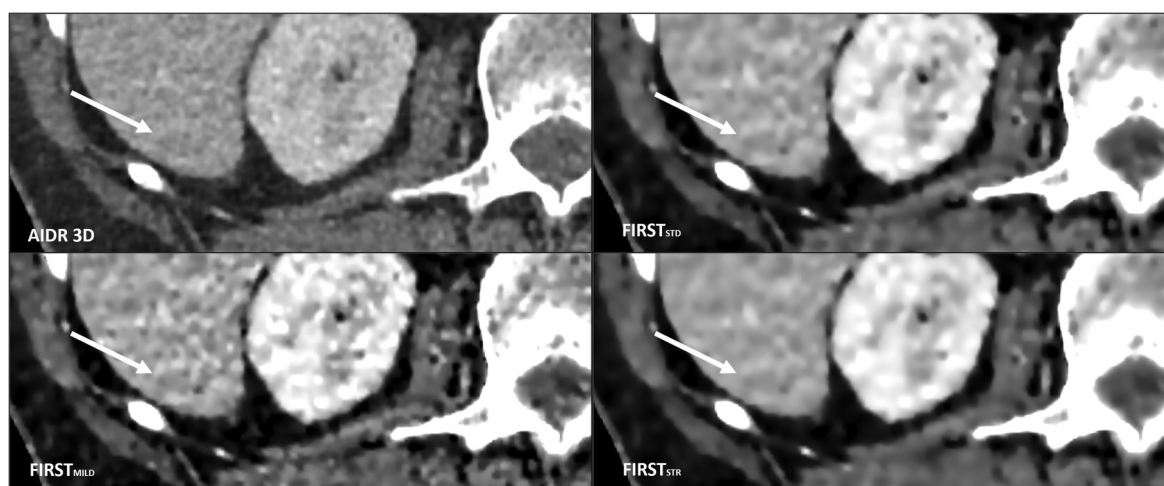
Axial computed tomography of the abdomen in venous phase, exemplary poorly contrasted focal liver lesion in all reconstruction methods (arrows).
